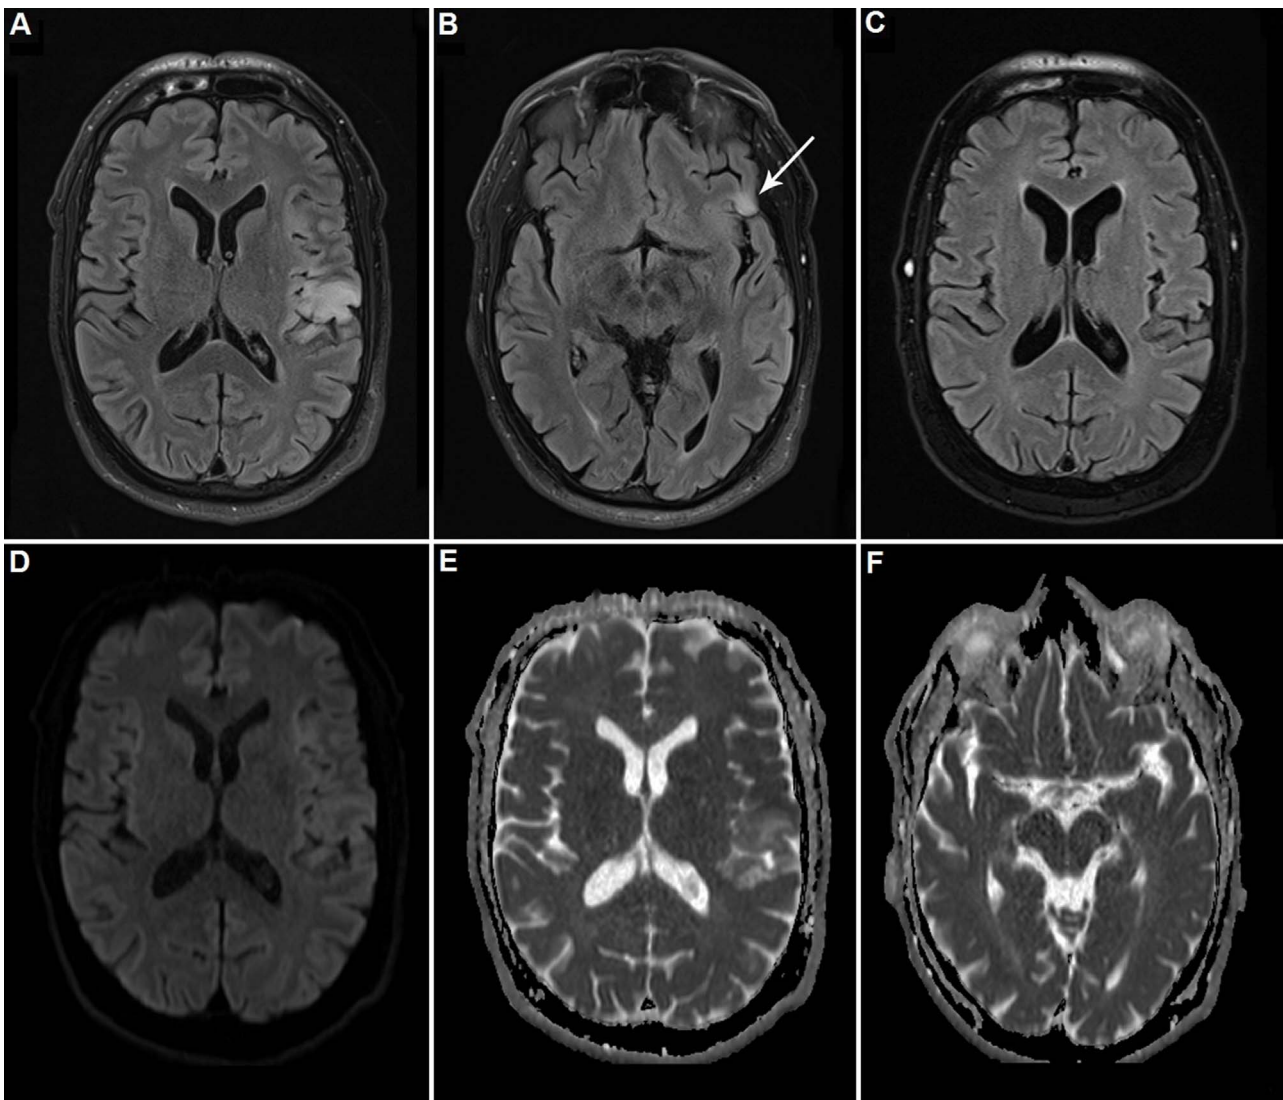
MRI of the brain at first presentation. Axial FLAIR images show a large area of hyperintensity in the left insular cortex (A) and a small area of hyperintensity (B) in the left frontal operculum (white arrow). Axial FLAIR image (C) after discontinuation of Nivolumab shows normal findings with complete resolution of all T2 hyperintensities. At axial diffusion-weighted MR image ($b = 1.000 \text{ s/mm}^2$) only very slight increase in signal intensity in the area of the left insular cortex and slight decrease of signal intensity on the apparent diffusion coefficient (ADC) map, corresponding to only very mild diffusion restriction (D-E). No diffusion restriction is seen in the lesion in the left operculum (F).
